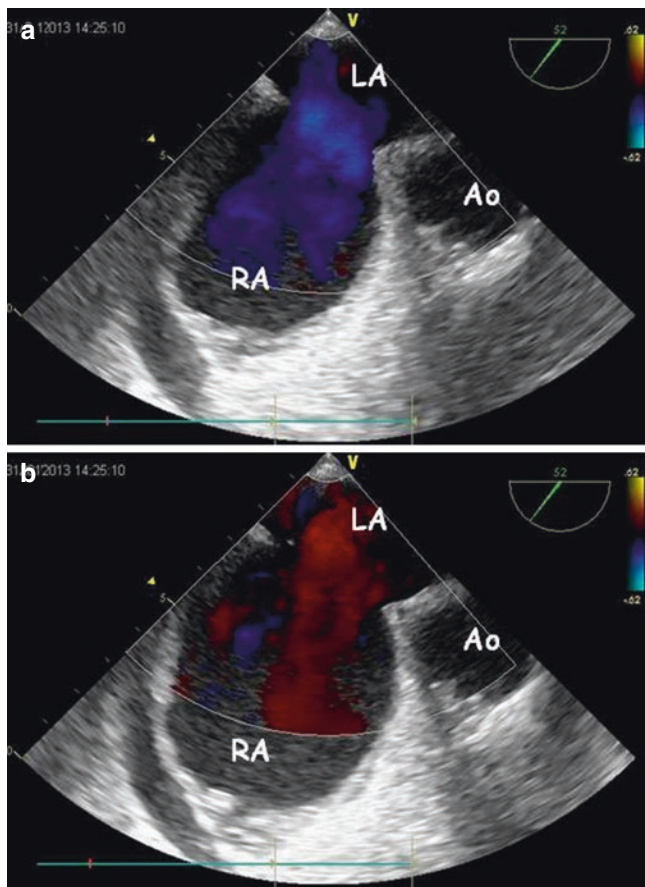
ASD closure in a patient with pulmonary atresia and intact ventricular septum (PA-IVS) submitted to right ventricular (RV) decompression. Bidirectional left-to-right (a) and right-to-left (b) ASD shunt as imaged at TEE color Doppler analysis. Ao aorta, LA left atrium, RA right atrium
